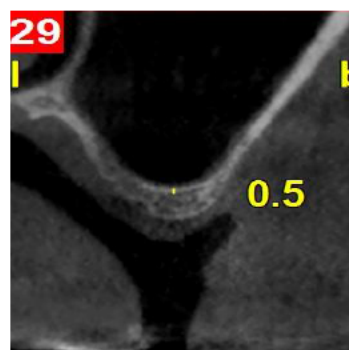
Measuring sinus floor thickness in CBCT cross-sectional image.
